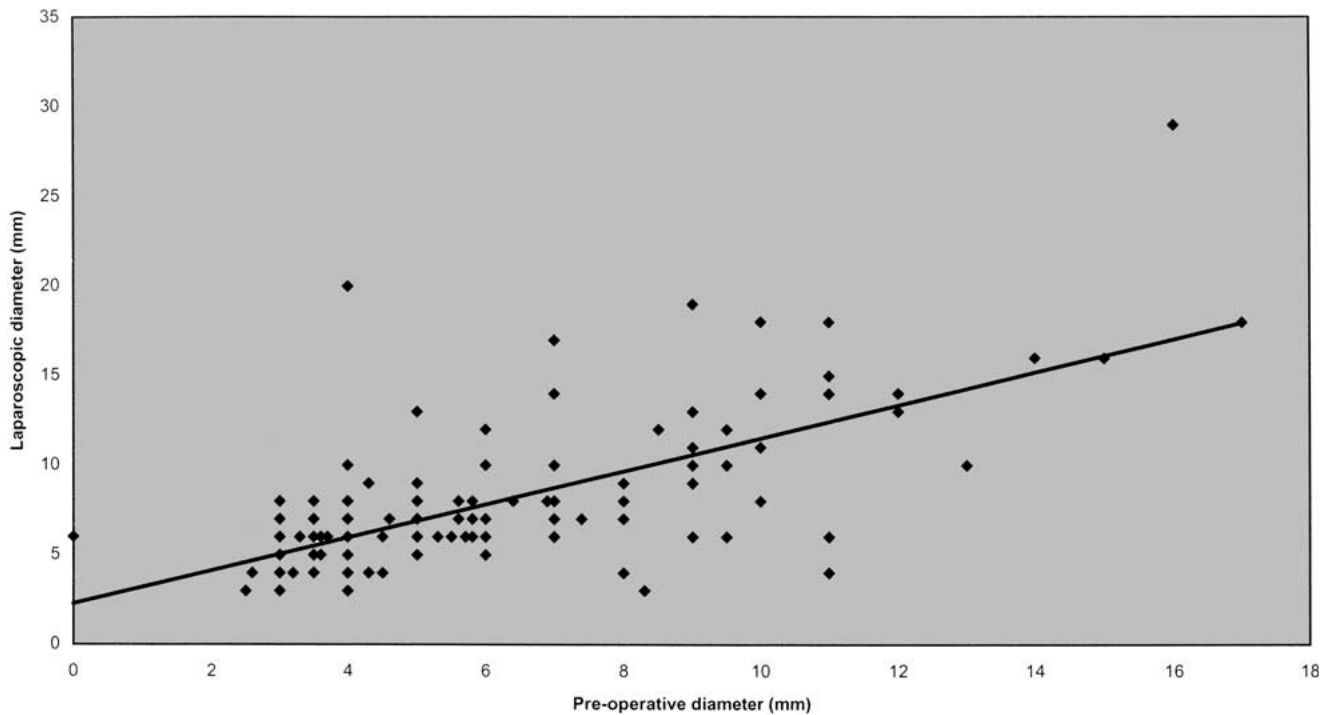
A comparison of preoperative and laparoscopic ultrasound common bile duct.
